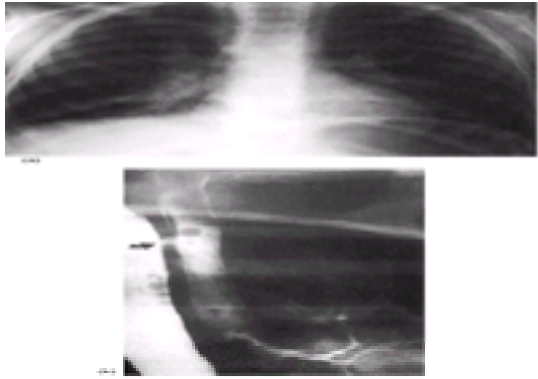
(a) Chest radiograph obtained in a 30-month-old boy who presented with recurring pulmonary infections. Each responded to therapy but soon recurred. They involved primarily the right lower lobe. (b) Barium swallow demonstrated an H-type tracheo-esophageal fistula (arrow). Extreme caution must be taken in performing this study when looking for this type of fistula. The patient must be in the lateral position and barium slowly instilled into the esophagus under fluoroscopic control to see the fistula.
